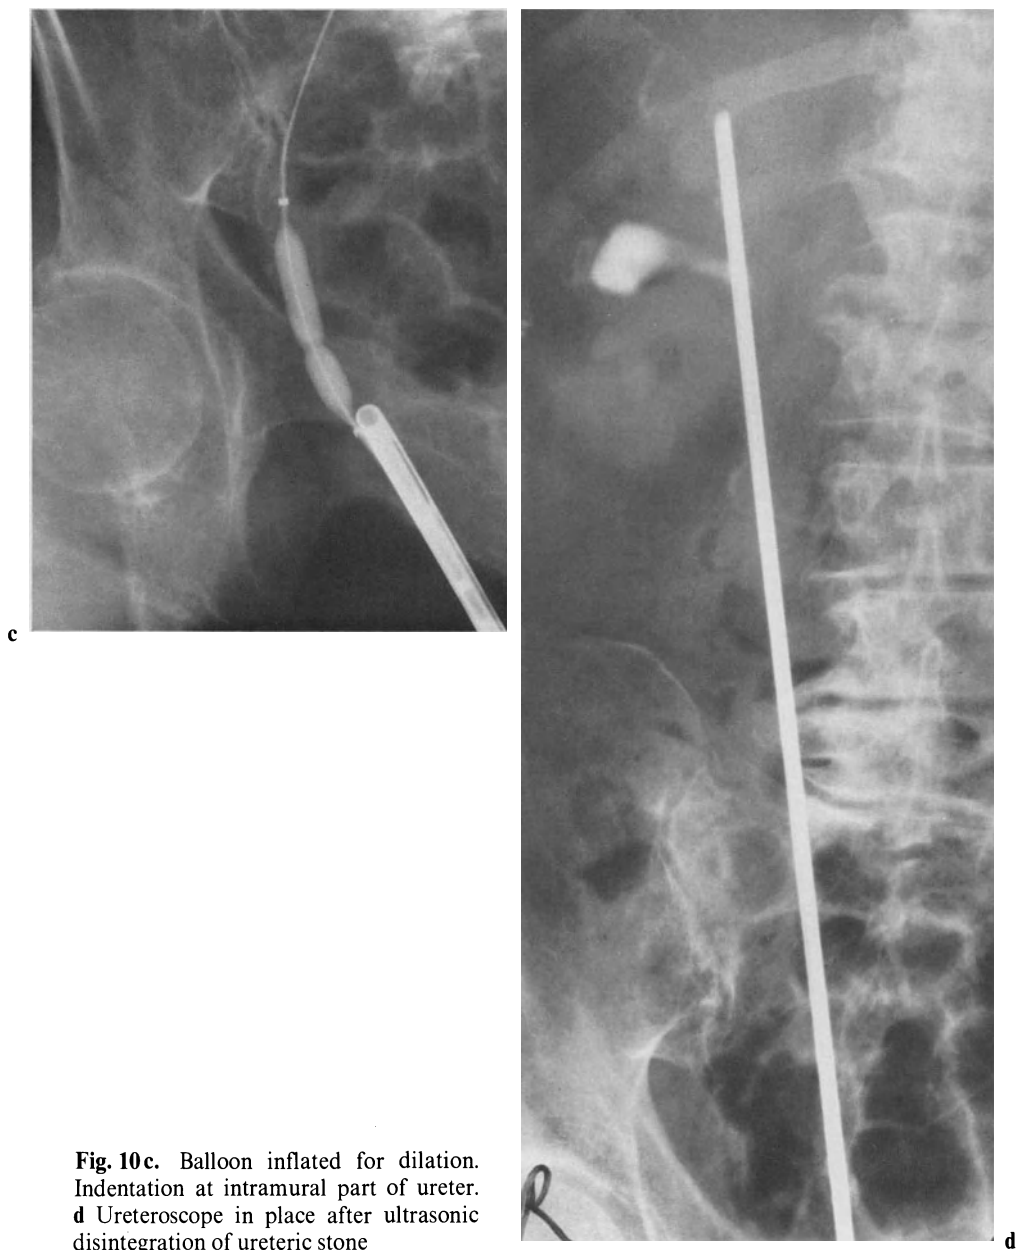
Balloon inflated for dilation. Indentation at intramural part of ureter. d Ureteroscope in place after ultrasonic disintegration of ureteric stone
